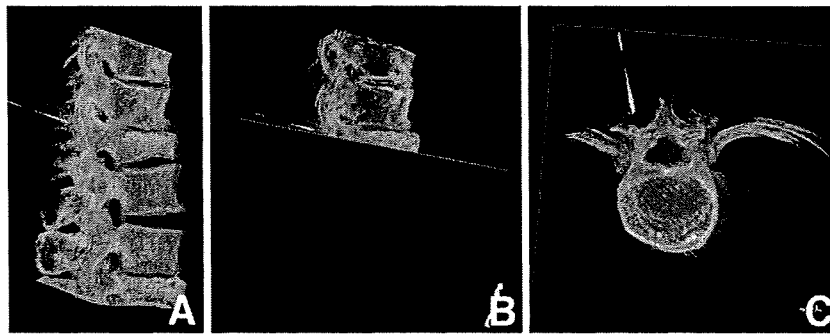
Three-dimensional radiographs after insertion of the pilot needle. A: Lateral view; B: lateral view, including the plane parallel to the pilot needle; C: axial view.
